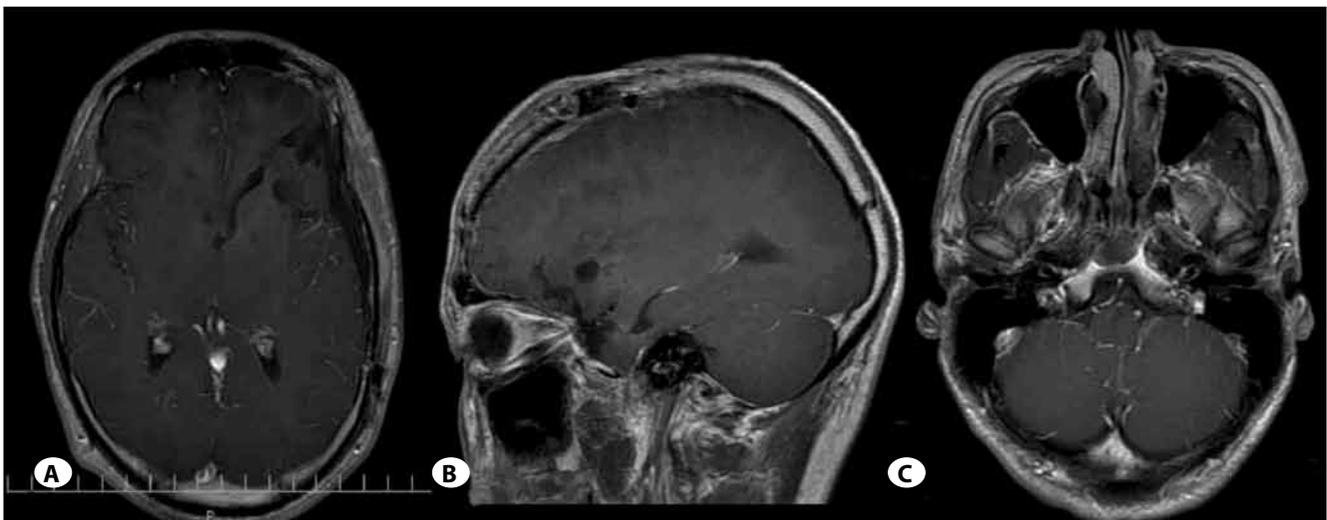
A Gd-enhanced (A) axial and (B) sagittal T1-weighted MRI portrayal after radiotherapy and chemotherapy indicates no residual tumor (refer to Figure 1 for abbreviations). (C) There was no mass in the posterior fossa after treatment with chemotherapy and radiotherapy.
